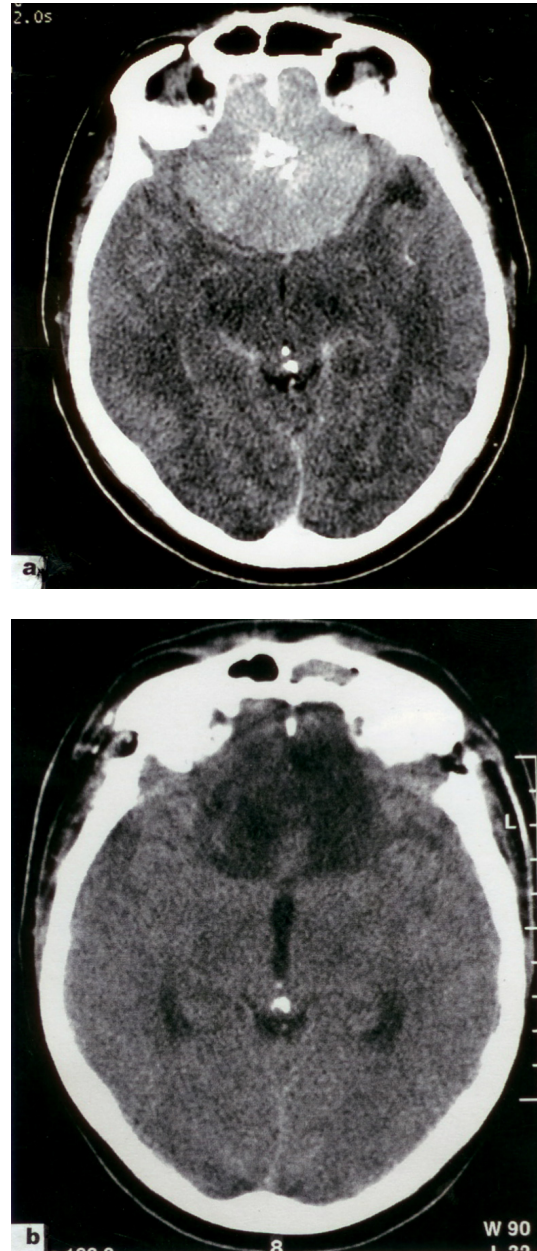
a) Preoperative axial CT scan with contrast enhancement showing a large olfactory groove meningioma in a 56 years old male, b) Postoperative contrast axial CT scan after tumor removal through the bifrontal approach
